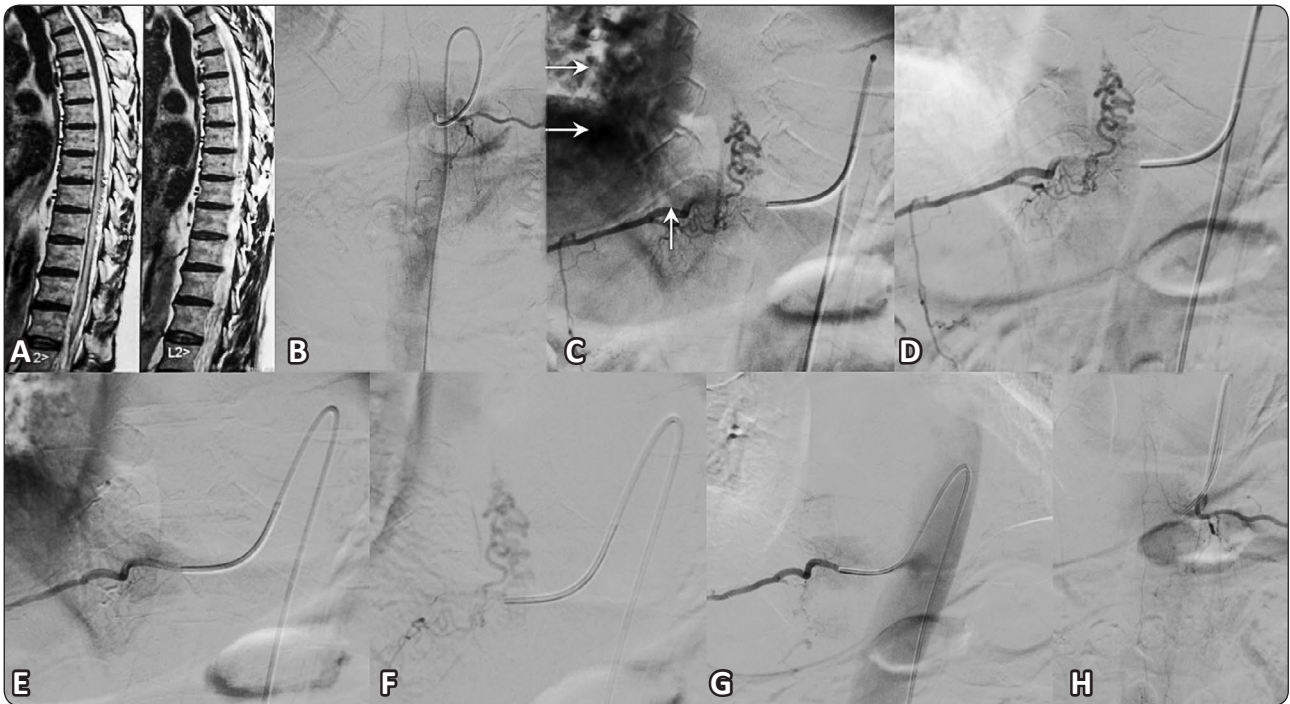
a-h. A Case of 64-years-old, Male with bilateral lower extremity weakness, urinary disorder, defecation dysfunction. a, MRI dorsal spine , sagittal T2 weighted images showing medullary signal from thoracic 6 down to conus, associated with a tuft with abnormal tortuous flow signal voids overlying the dorsal aspect of the cord at levels of thoracic 8,9,10,suggesting SDAVF. b : Spinal DSA , AP view with injection of left 9th thoracic intercostal artery, filling of artery of Adamkiewicz (anterior spinal artery contribution). c,d: Spinal DSA AP with injection of right 10th thoracic intercostal artery, filling of a SDAVFwith pial venous drainage. e :Spinal DSA AP with superselective injection of the fistula feeder, showing the fistulous site and draining pial veins. e, Subtracted images AP Spine view, showing f,g, Spinal DSA AP view control injection showing no more filling of the fistula with the glue cast occluding draining vein and fistula refluxing into the feeder. h : Spinal DSA, AP view with injection of left 9th thoracic intercostal artery, showing good filling of artery of Adamkiewicz post-treatment
